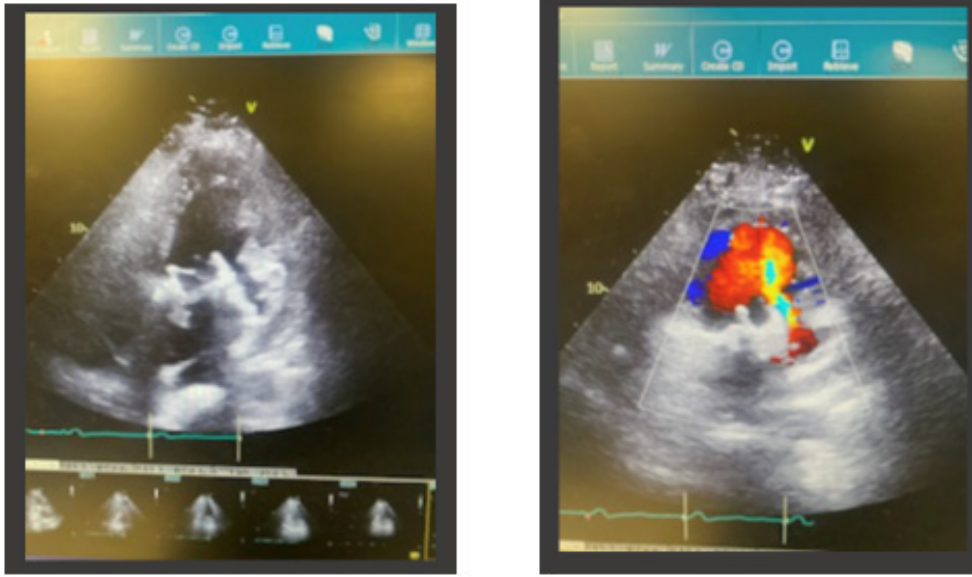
Image on Left: Transthoracic echocardiogram, apical long axis view, with ventricular rupture present.
